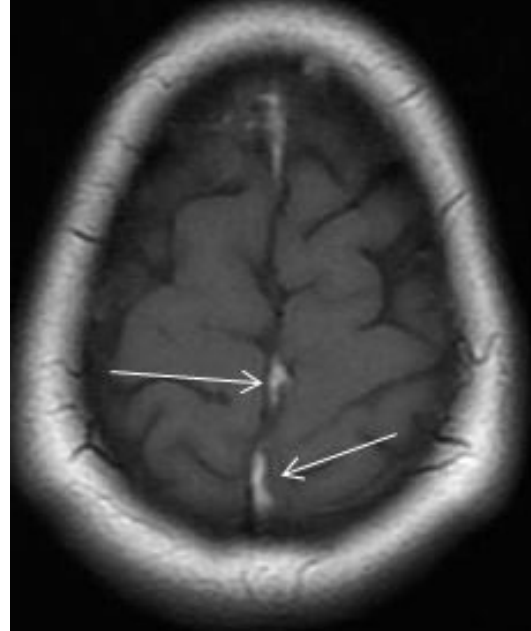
Axial T1W MRI demonstrates thrombosis throughout the superior sagittal sinus (arrows).
